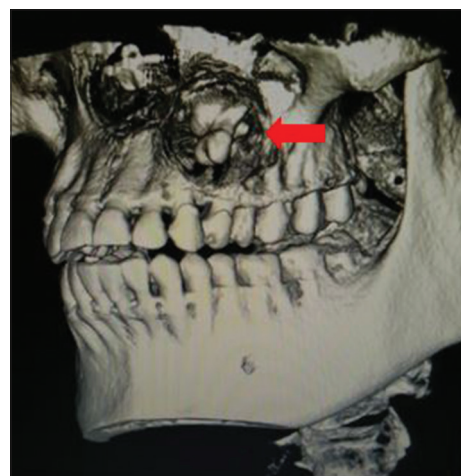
Three-dimensional cone-beam computed tomography image showing the lesion and the associated impacted teeth
